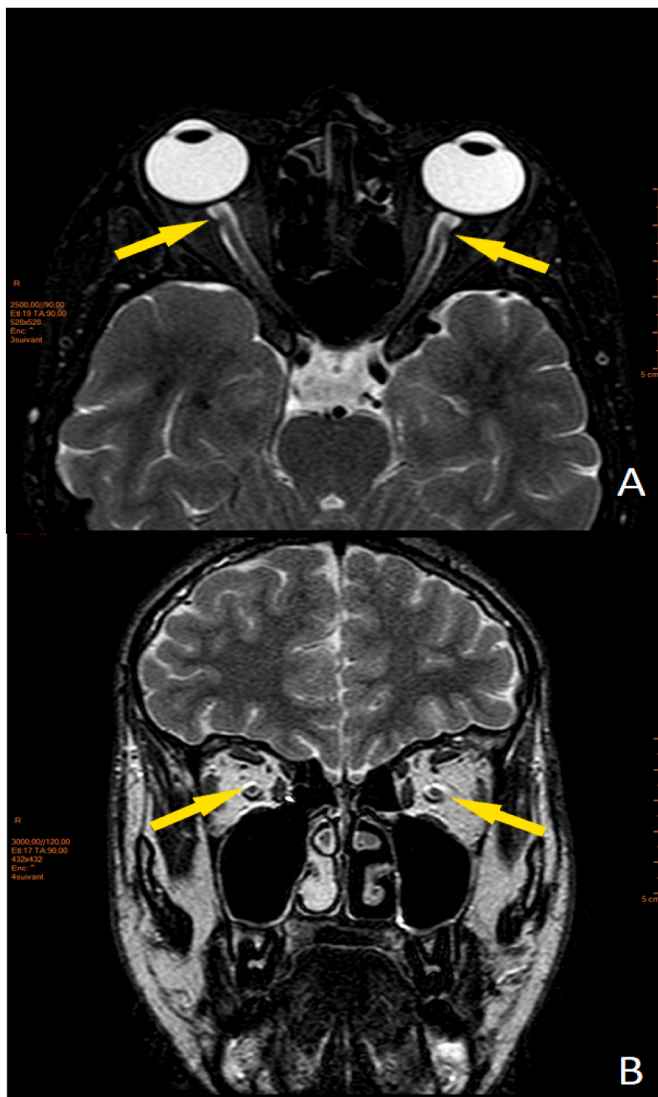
A and B: axial and coronal section of Encephalic MRI in T2 sequence showing a pathological hyper signal of the optic nerves bilaterally.
